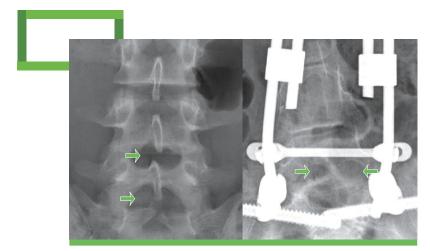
Pre-lumbar puncture X-rays
